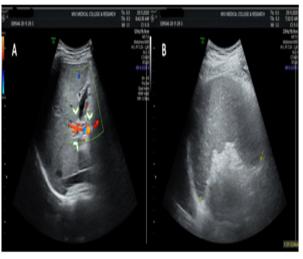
18-year-old male with EHPVO. (A & B) Ultrasound and color Doppler images demonstrate cavernous transformation of the portal vein (arrow heads) on the left image and splenomegaly with hyperechoic Gamma - Gandy bodies the right image
